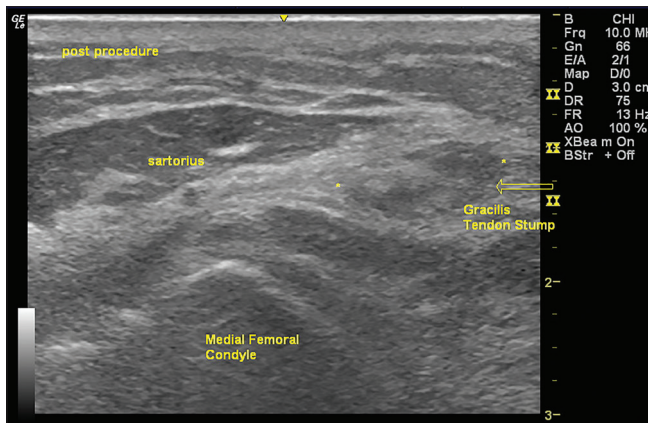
Postoperative ultrasound – Case 1. A 31-year-old male with right knee pain. Postoperative ultrasound appearance of the right medial knee after sartorius and gracilis hamstring harvest. The gracilis tendon is now absent deep to the sartorius muscle and instead seen as a large hypoechoic retracted stump positioned more posteriorly (asterisks and arrow).
